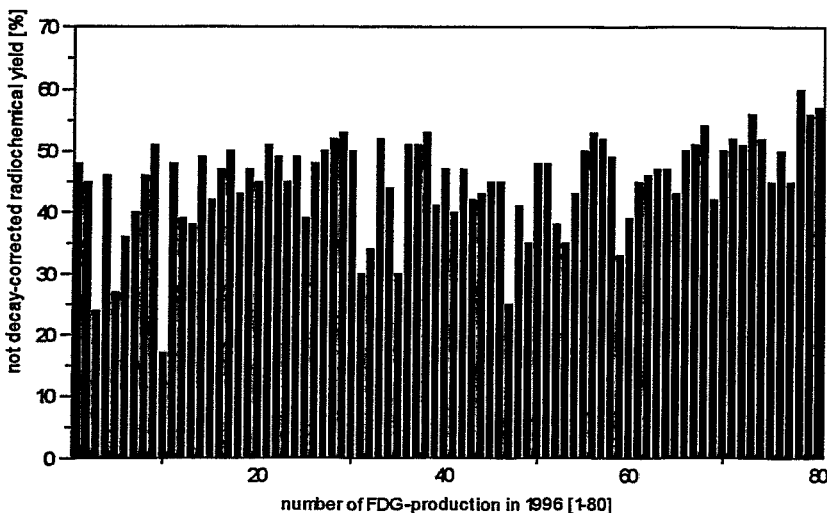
Radiochemical yield of  $^{18}\text{F}$ -FDG (not decay corrected) in 1996
